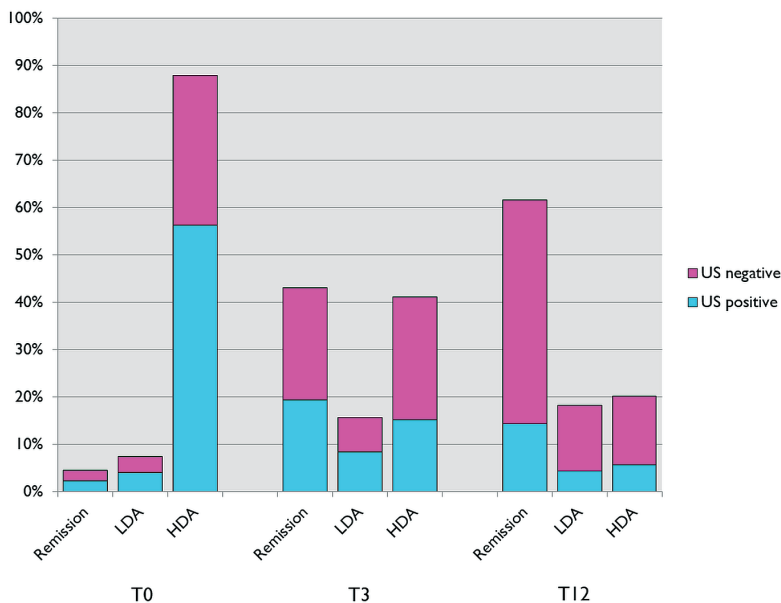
Distribution of early RA patients according to disease activity (DAS28) at baseline (T0), three months (T3), and twelve months (T12). The green bar depicts the percentage of patients who have at least one US positive MTP joint. (HDA = high disease activity; LDA = low disease activity; US = ultrasound)
